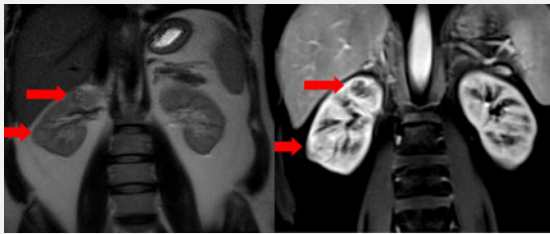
Preoperative MRI image of the patient. Upper arrows show papillary RCC type 1. Lower arrows show clear cell type RCC.
